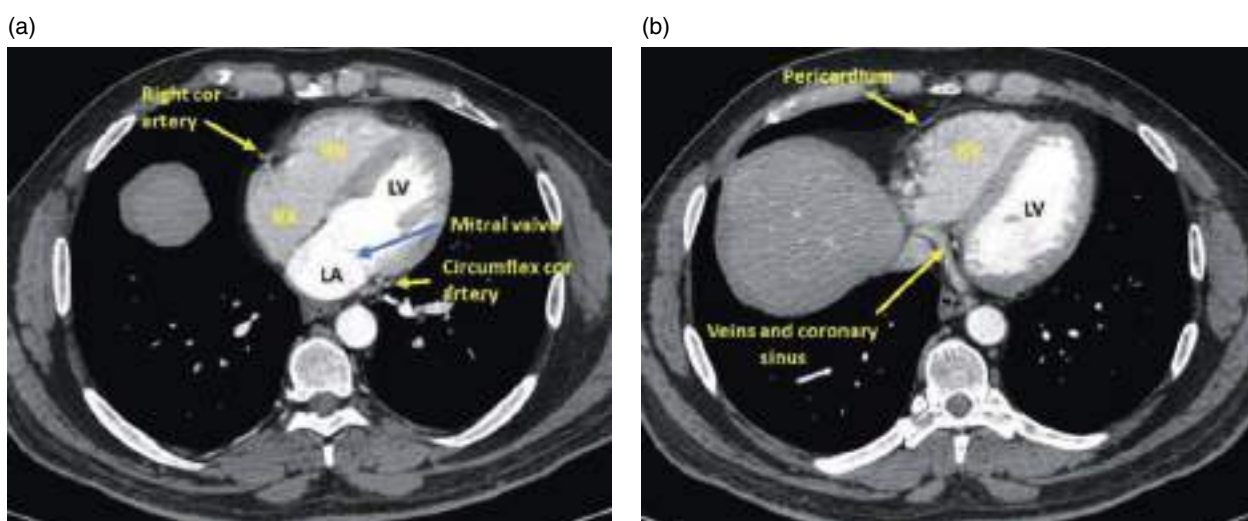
Normal cardiac anatomy. (a, b) Axial contrast-enhanced CT images (mediastinal window). RV, right ventricle; LV, left ventricle; RA, right atrium; LA, left atrium; LVO, left ventricular outflow tract; DA, descending aorta.
